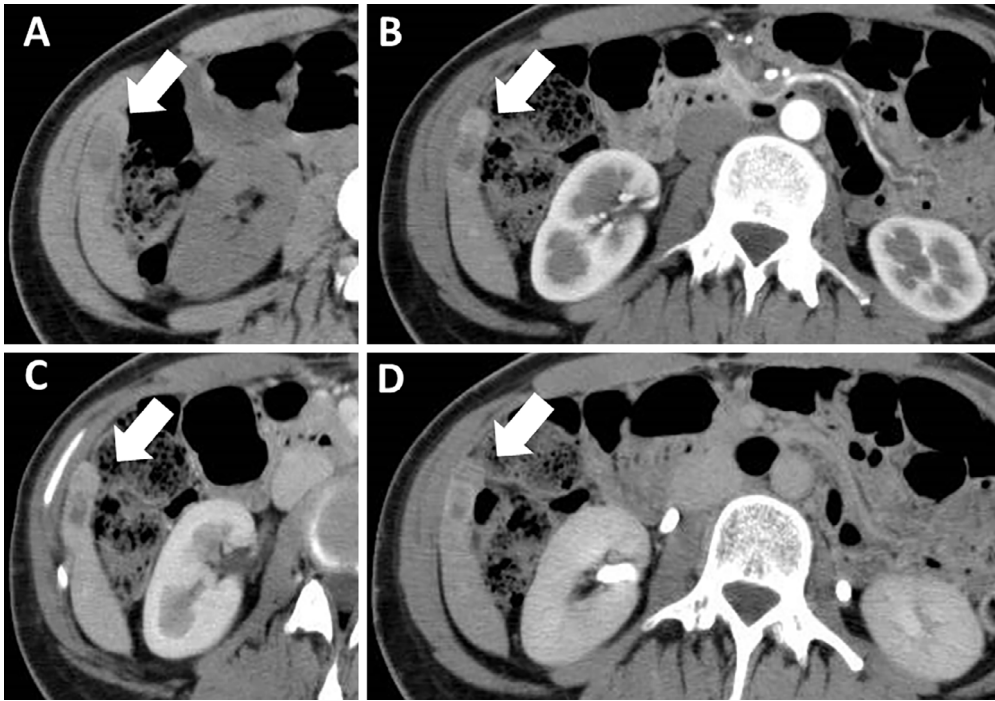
Dynamic computed tomography performed 3 months before the patient's admission showed a 11×25-mm, irregularly shaped mass (arrows) (A). The lesion was heterogeneously enhanced during the arterial phase (B) and washed out during the portal vein phase (C). It also showed hypointensity at the equilibrium phase (D).
